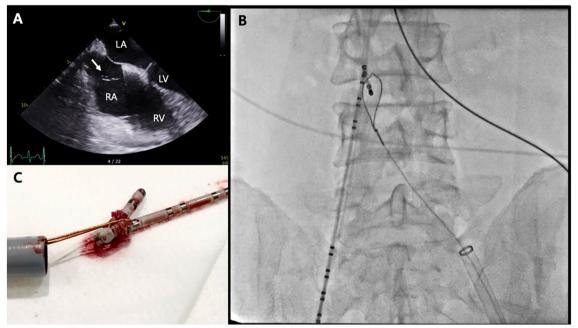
A The preprocedural transesophageal echocardiography findings showed the Chiari's Network in the RA (arrow). B A fluoroscopic image during the procedure. The duo-decapolar catheter tip folded by the Chiari's Network was captured at the iliac vein bifurcation area and successfully extracted by the 20-mm circular snare catheter (Snare Kit; Medtronic, Minneapolis, MN). C A photograph of the retrieved duo-decapolar catheter. Entangled fibrous tissue of the Chiari network is seen
